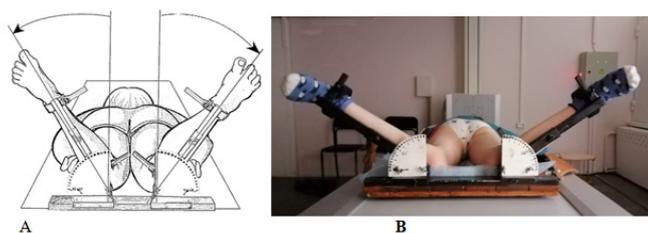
(A, B) The method of determining the clinical and radiographic parameters of the hip joint in patients with pathology of the abovementioned joint⁷ (positioning the patient and fixation with an orthopedic console.^{8,9})
